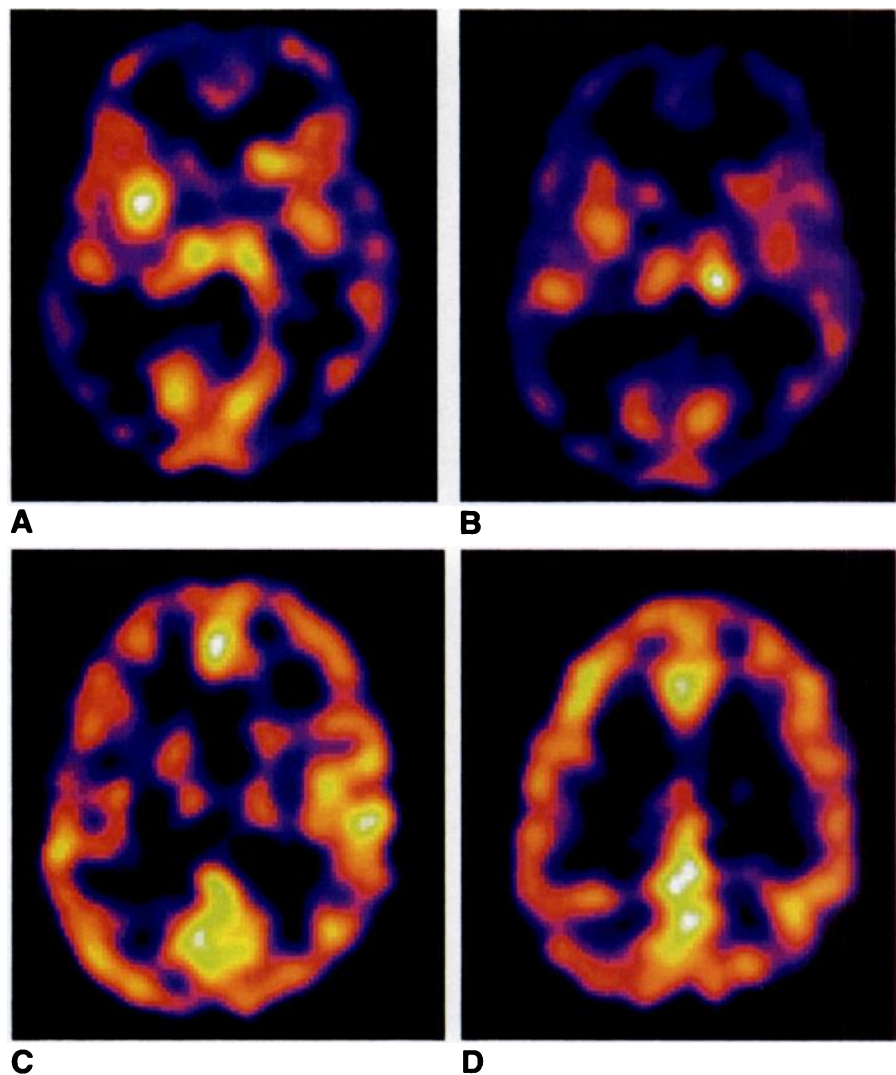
A–D, Axial SPECT images of a 37-year-old man with AIDS dementia complex. Multiple perfusion defects are present throughout brain.
